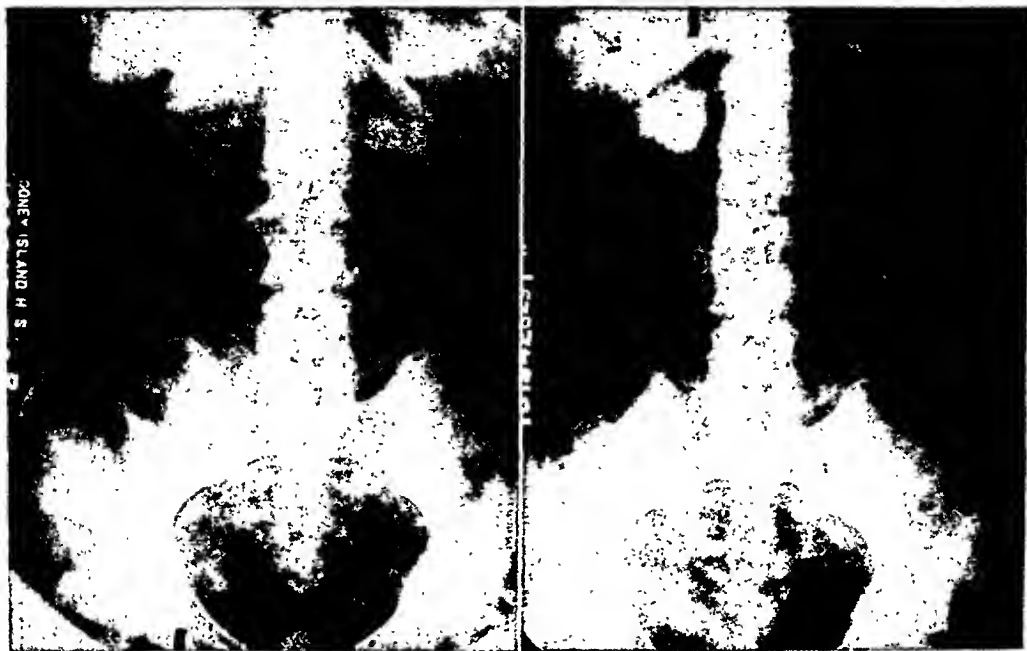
X-ray demonstrating large calculus.
